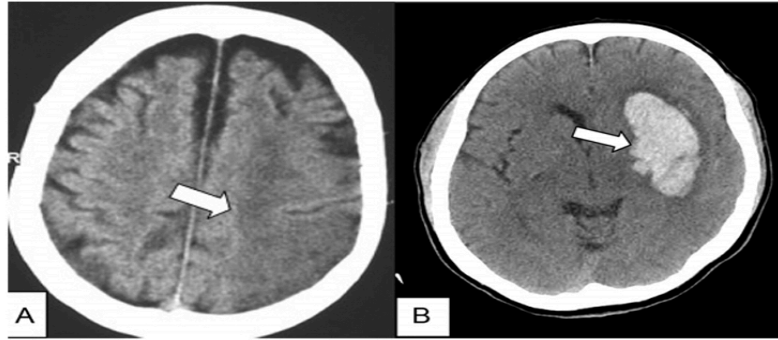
A) CT brain scan of patient shows parietal infarction (arrow), B) Left basal ganglia hemorrhage (arrow).
